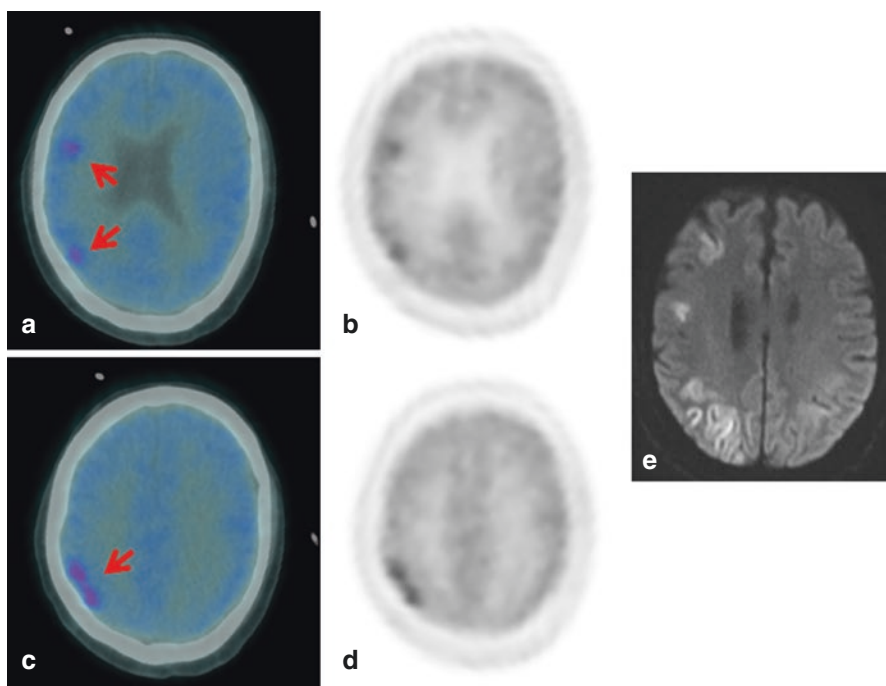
(a–e) A 64-year-old patient with background AL amyloidosis treated with chemotherapy, presenting with widespread myoclonus, confusion, seizures and reduced consciousness. Axial fused ^{18}F FDG PET/CT (a, c), axial PET (b, d) and DWI image (e) show focal increased cortical uptake in right frontal and right parietal lobes (a–d, arrows), which correspond to areas of restricted diffusion on MRI (e), raising possible vasculitis secondary to cerebral amyloid angiopathy.
